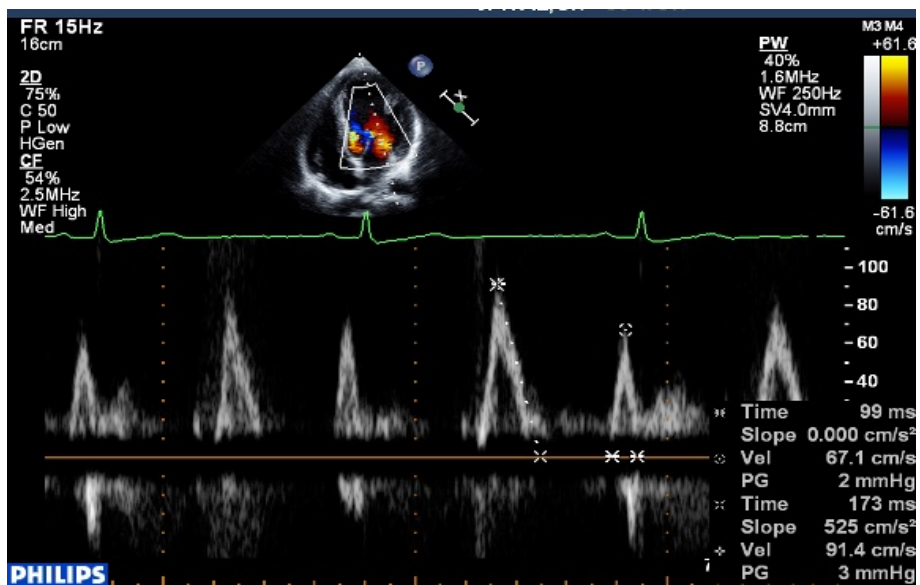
Transmitral doppler showing E value of 91.4 cm/s, A value of 67.1 cm/s and DT of 173 msec, suggestive of normal filling pattern.
